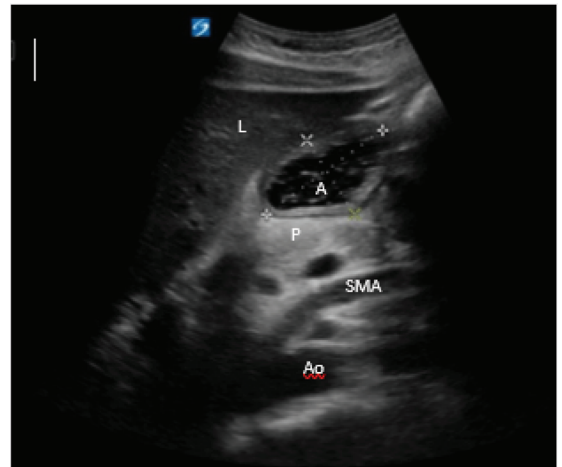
Shows the gastric ultrasonography to measure gastric volume: serosa-serosa.
